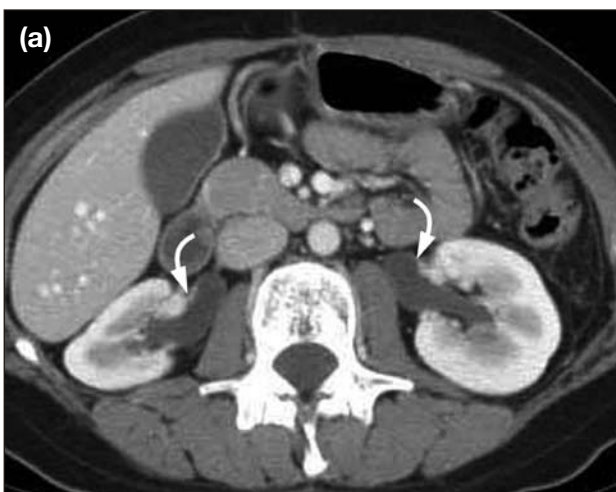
Contrast-enhanced axial computed tomography image of (a) the upper abdomen showing mild residual bilateral hydronephrosis (curved arrows), while the peritoneal metastases and malignant ascites have completely resolved; and (b) the liver showing resolved liver lesions at the level of the hepatic veins (black arrows).
